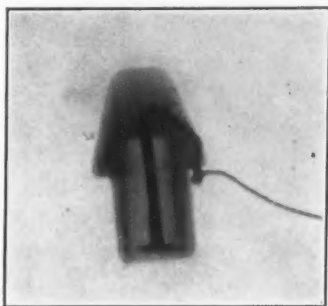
Roentgenogram of a completed electrode.
